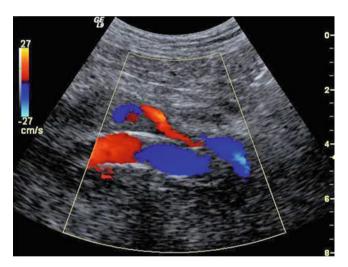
Color Doppler image showing a Type 1 endoleak at the left iliac limb distal fixation sites
